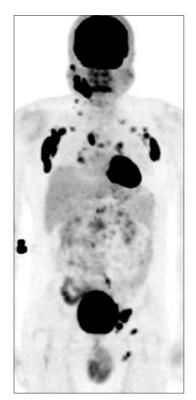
Maximum intensity projection fluoro-D-glucose positron emission tomography/computed tomography image demonstrated multifocal fluoro-D-glucose avid generalized lymphadenopathy (maximum standardized uptake value 13.8) with the pattern of hypermetabolic lesions mimicking lymphoma
